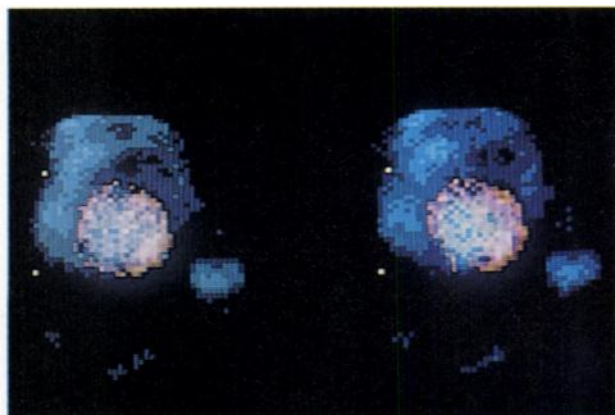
(Top, left) Tc-99m PPI myocardial scintigrams superimposed on blood-pool scintigrams are shown in patient with "donut" Tc-99m PPI pattern of uptake. Note intense Tc-99m PPI uptake (orange) with central defect (white) superimposed on cardiac blood pool (blue). Diastole is shown at left and systole at right.
